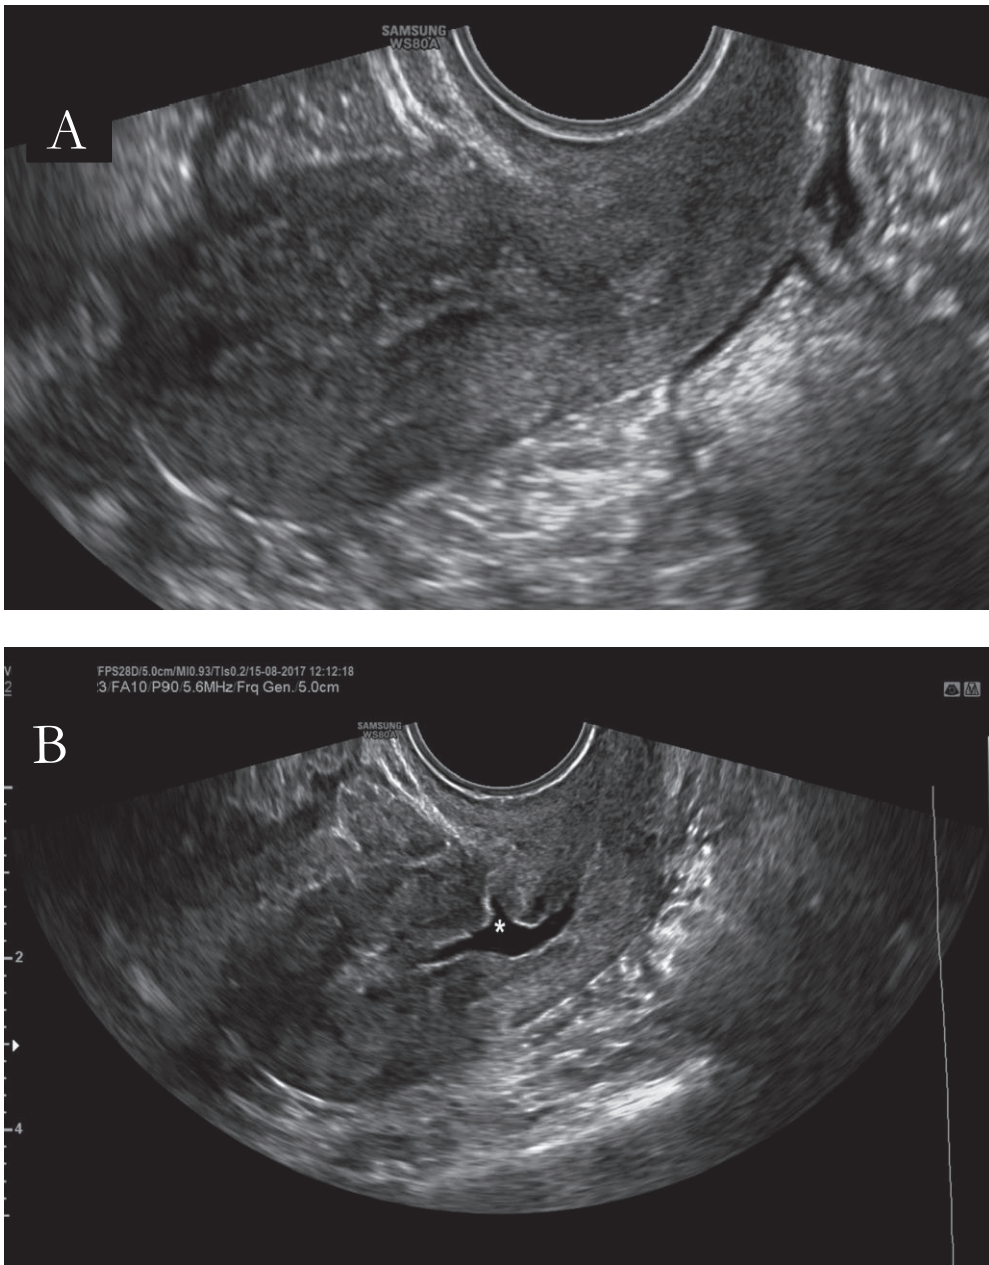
A) Transvaginal ultrasonography showed no visible anechoic defect at the uterine isthmus in a patient with one previous Cesarean delivery. B) After saline administration in sonohysterography, a triangular-shaped isthmocele was detected (asterisk)
